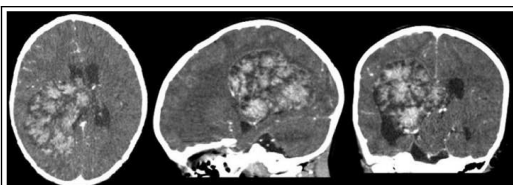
CT Head with IV contrast
